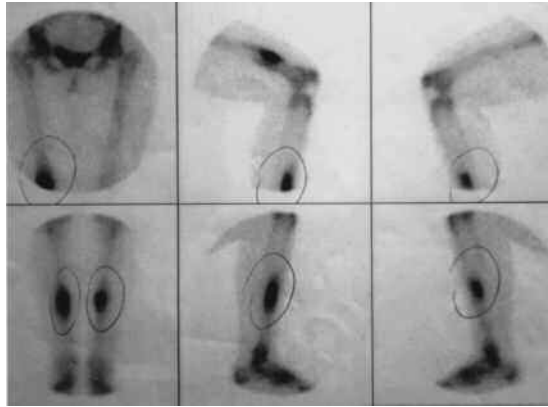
Bone scintigraphy revealed asymmetrical increased uptake in tibiae, femurs, and humerus.
